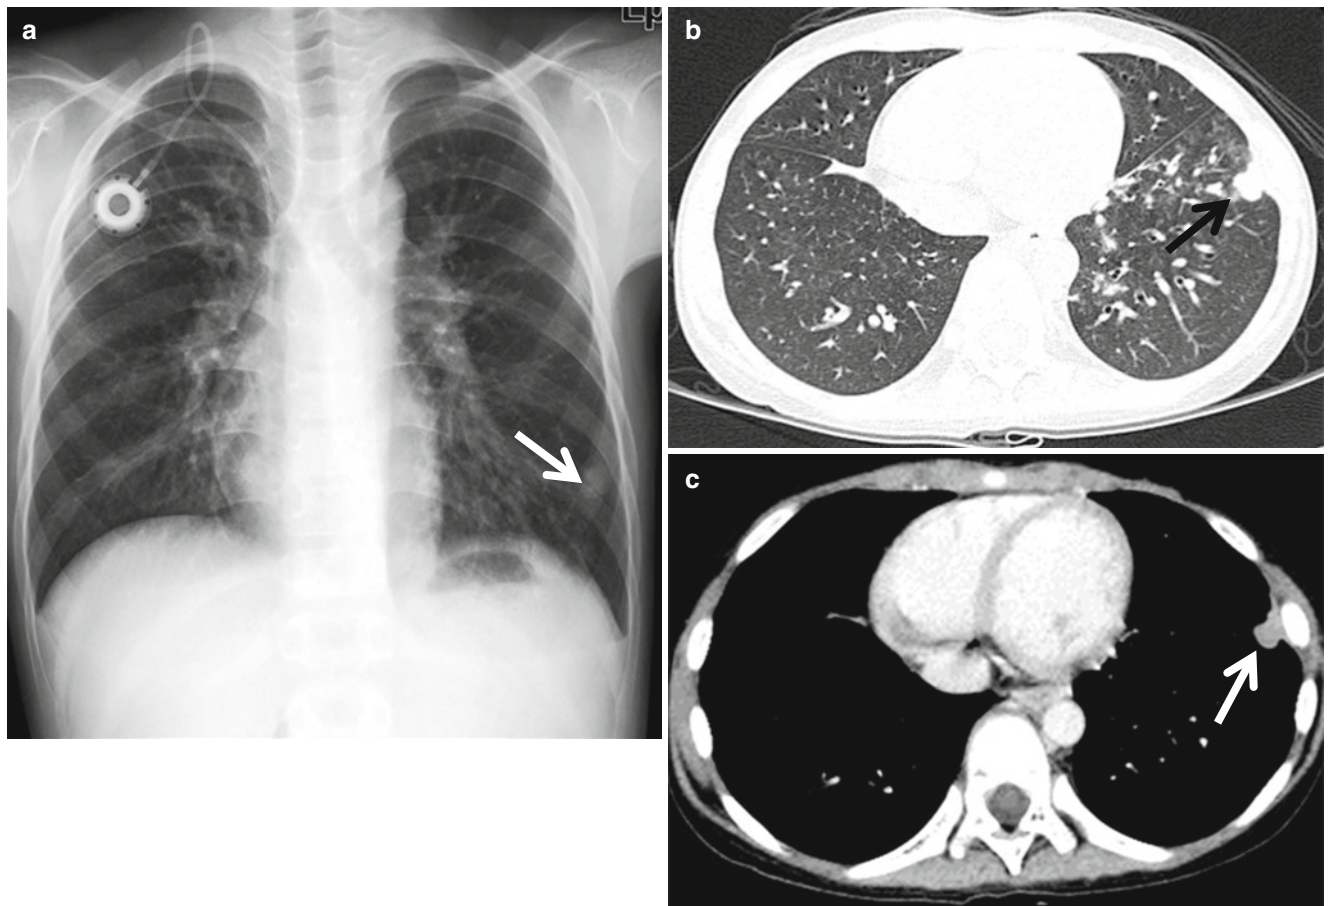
Solitary pulmonary metastasis in a 13-year-old boy with recurrent Wilms tumor. (a) Plain radiograph shows a 15 mm nodule (arrow) in the periphery of the left lower lobe. (b, c) CT with lung
